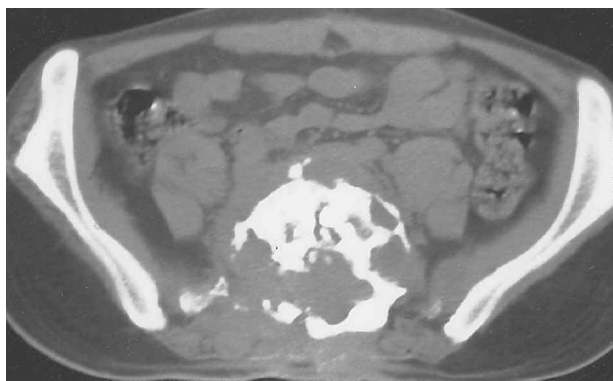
Axial CT scan at the S1 level showing hydatid disease of bone causing destruction vertebral bone, invading the canal and compressing the dural sac (case 9).
